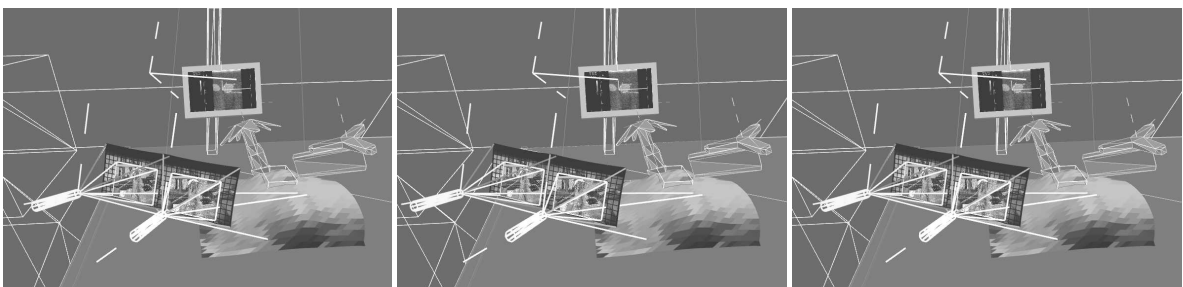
This image shows the so-called “control” view of our AR system. This view displays dynamic avatars of all objects in the system, from an arbitrary operator-controlled viewpoint. The object in the foreground is the head-mounted display, with video-camera imagery. Farther back, a model of the surface of the patient can be seen, with the motion-tracked ultrasound transducer and biopsy needle floating above it (cf. Fig. 1). In the background, a virtual ultrasound monitor shows the ultrasound video texture for reference purposes.
